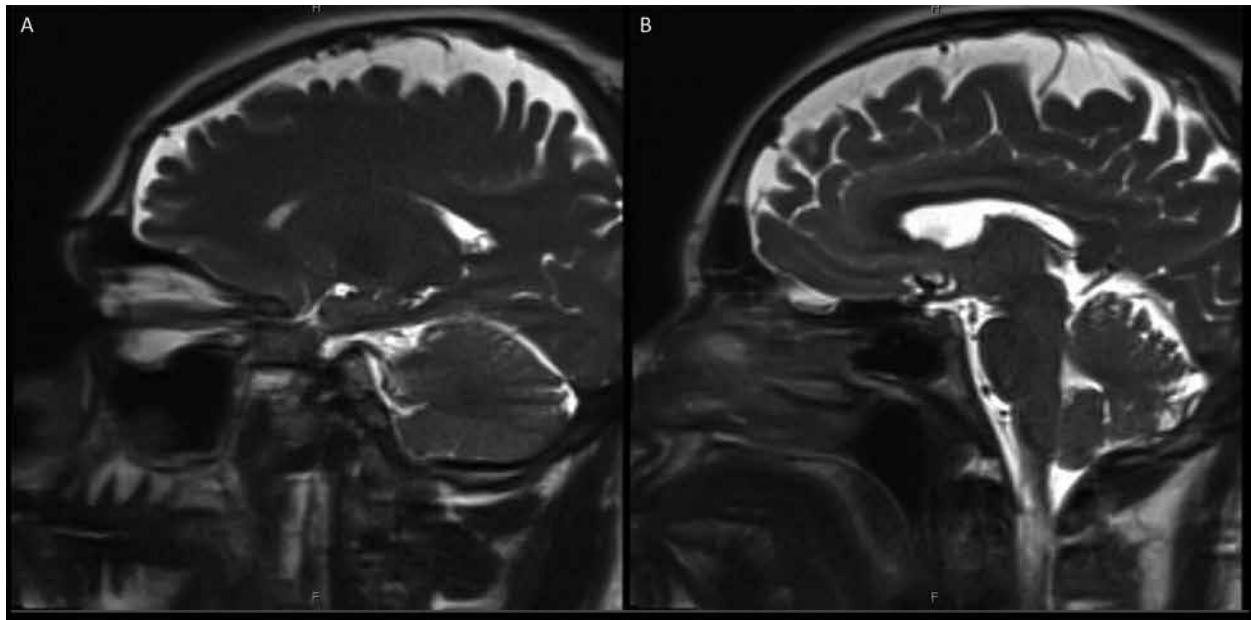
A: MRI showing meningeal enhancement and subdural collections. B: MRI showing pituitary enlargement and meningeal enhancement
